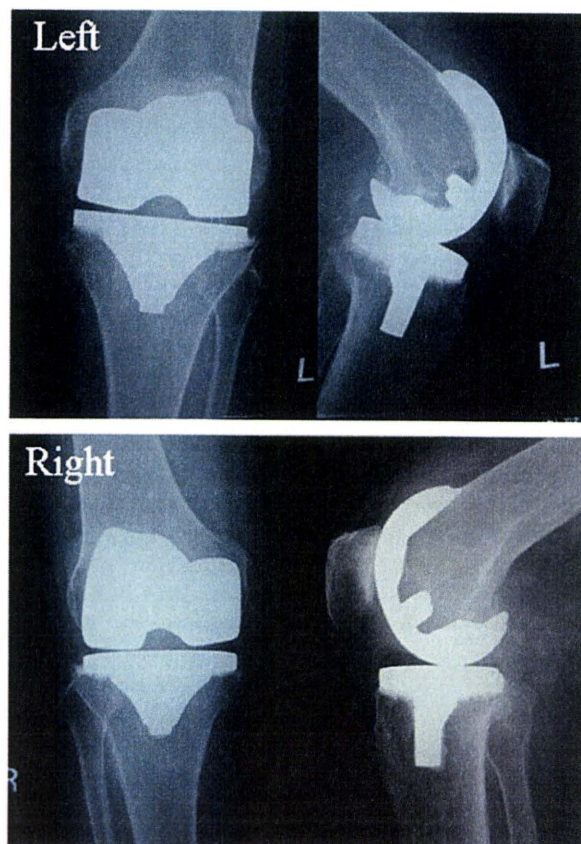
Radiographs at 7 years postoperatively, suggesting polyethylene insert wear or creep.
